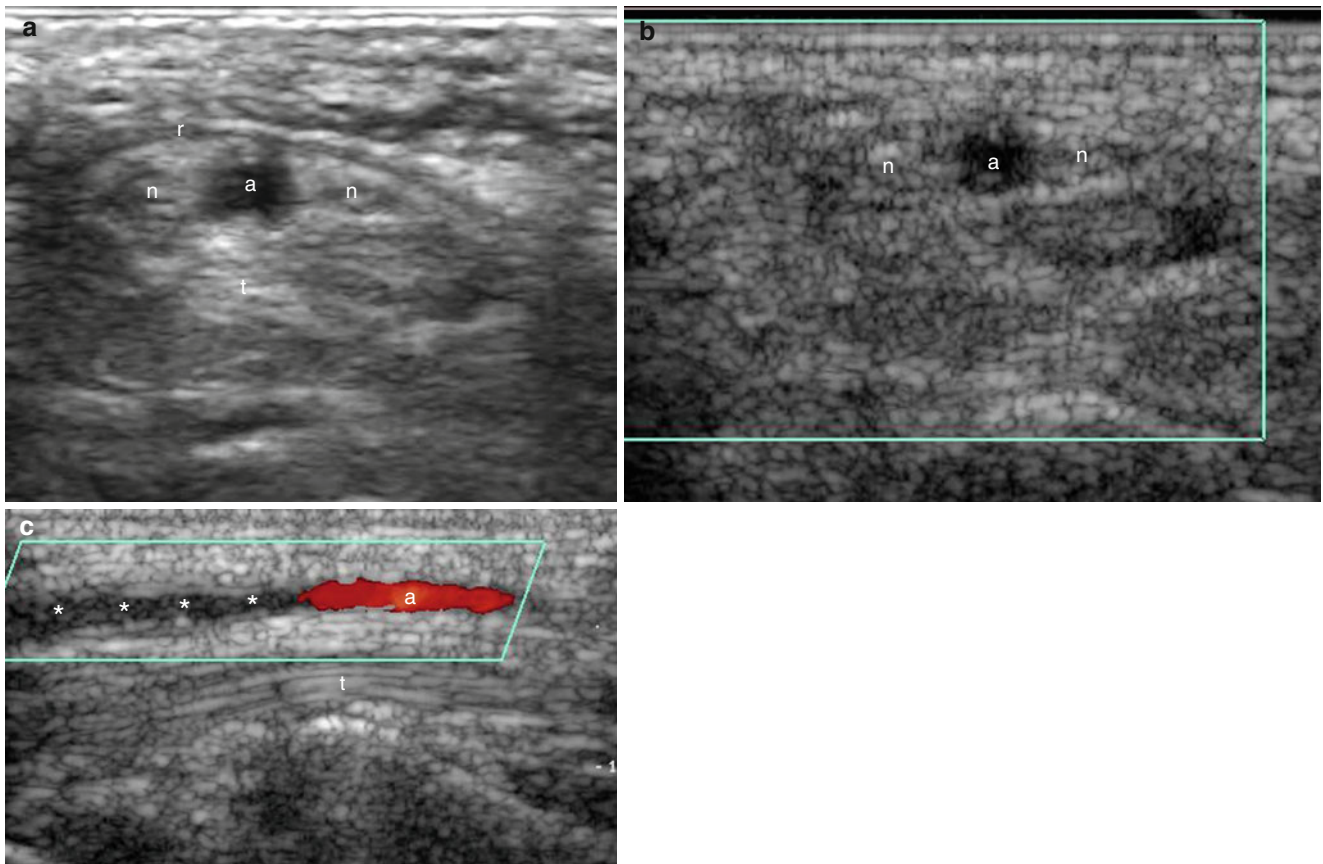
(a, b) Bifid median nerve and persistent median artery. (a) Ultrasound of the wrist (transverse view). Two branches of the median nerve (*n*) are separated by a dilated persistent median artery (*a*). (b) Color Doppler ultrasound (longitudinal view) showing the vessel lumen
